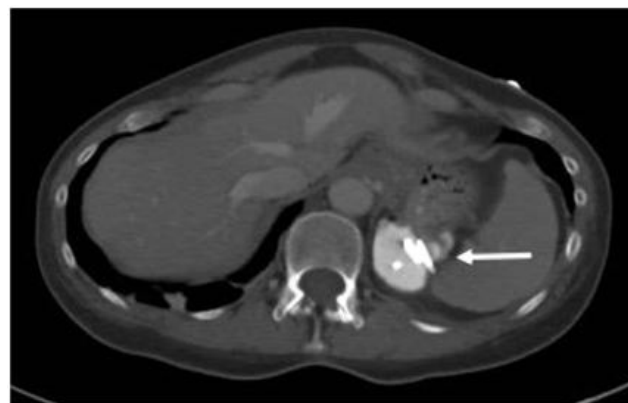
CT scan showing a large diverticulum (33.3 × 28.8 × 26.9 millimeters) protruding from the gastric fundus with hemoclips in situ (white arrow).
